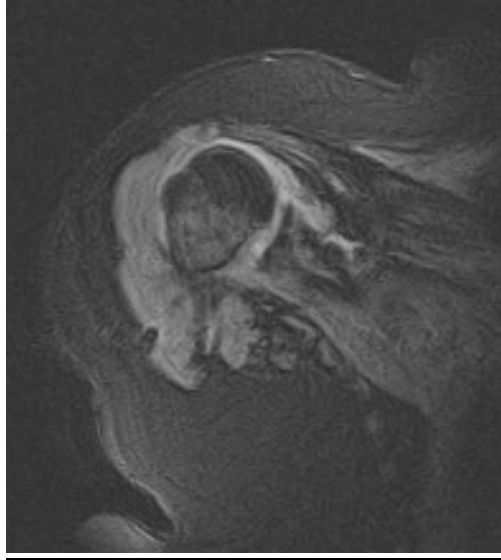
MRI shoulder with cuff tear
